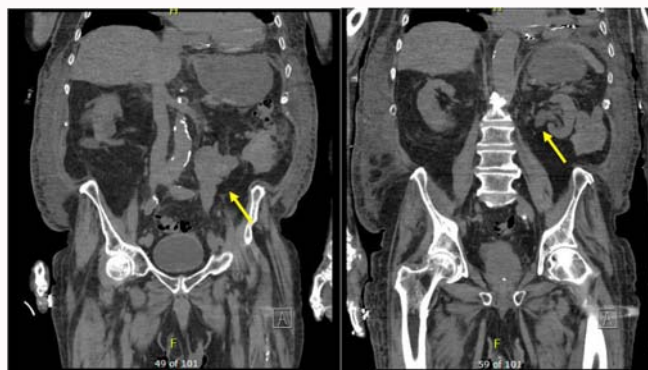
Follow up CT abdomen/pelvis showing large left retroperitoneal mass causing left hydronephrosis.
